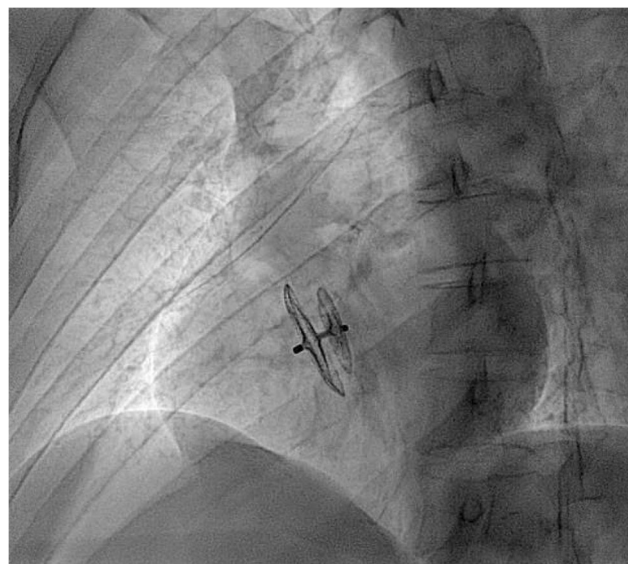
A lateral X-ray view of an Amplatzer PFO occluder is shown with its larger disc in the right atrium and smaller disc in the left atrium
